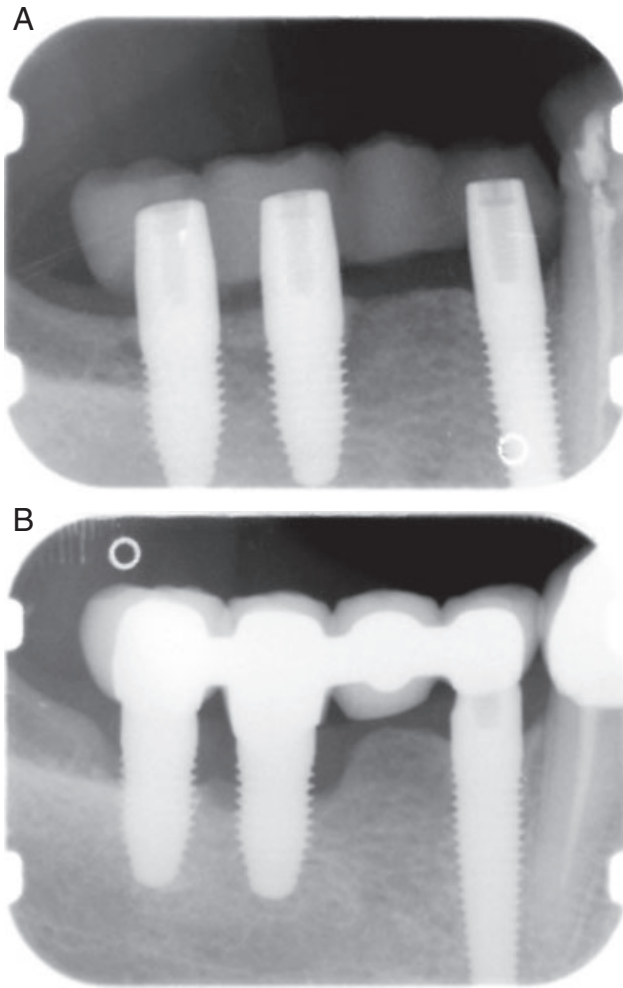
Radiographs of NobelDirect implants in the right mandible (A) at placement and (B) after 1 year of loading. Note the marginal bone resorption. The middle implants were surgically removed after 2 years of loading.
